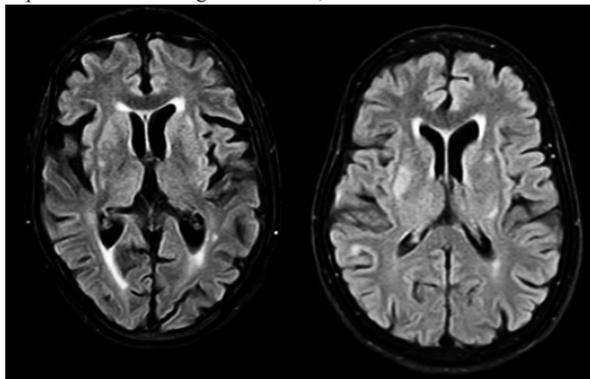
MRI brain images of the two patients who developed chronic chorea showing small vessel ischemic changes in bilateral striatum . Source : department of radiodiagnosis DSMC ,Siruvachur
